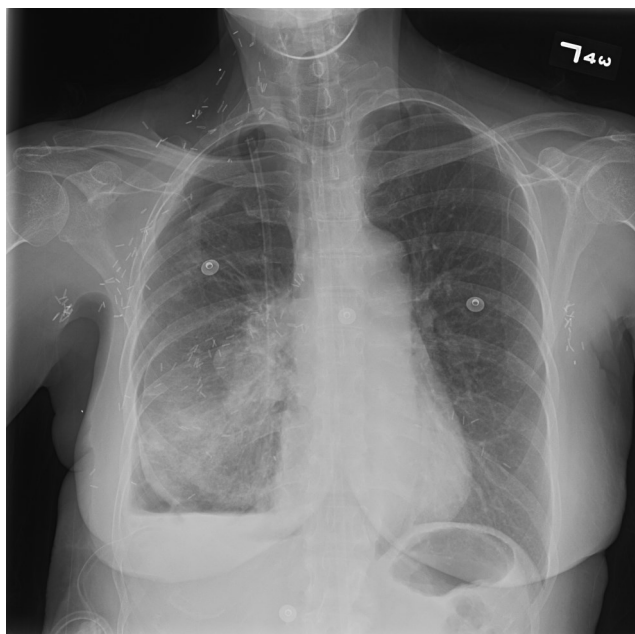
Chest x-ray after IPC placement and drainage of 650 cc of fluid with air. Drainage was stopped due to chest pressure. IPC insertion was done 24 hours after therapeutic thoracentesis. Daily drainage of fluid using IPC was continued.
